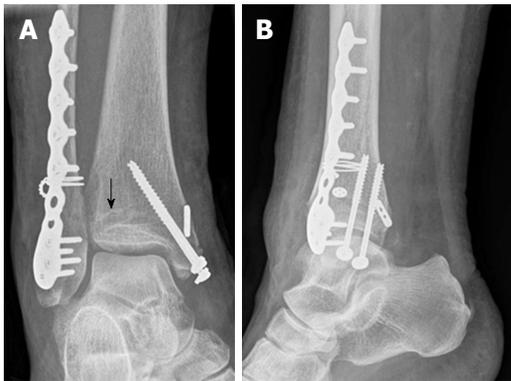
Postoperative X-rays of the ankle from Figure 8 showing anatomic reduction of the syndesmotic injury (A, B). The tibial bone tunnel for the *InternalBrace*™ is visible (black arrow).
